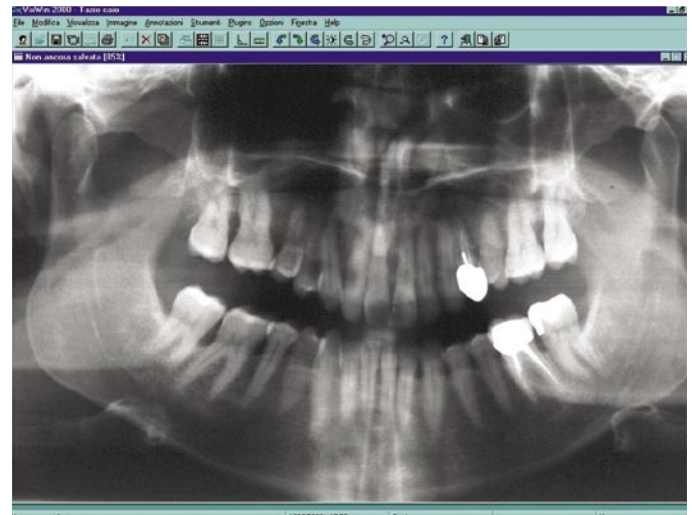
Also orthopantomographic examinations may be performed through radiovideographic systems.
